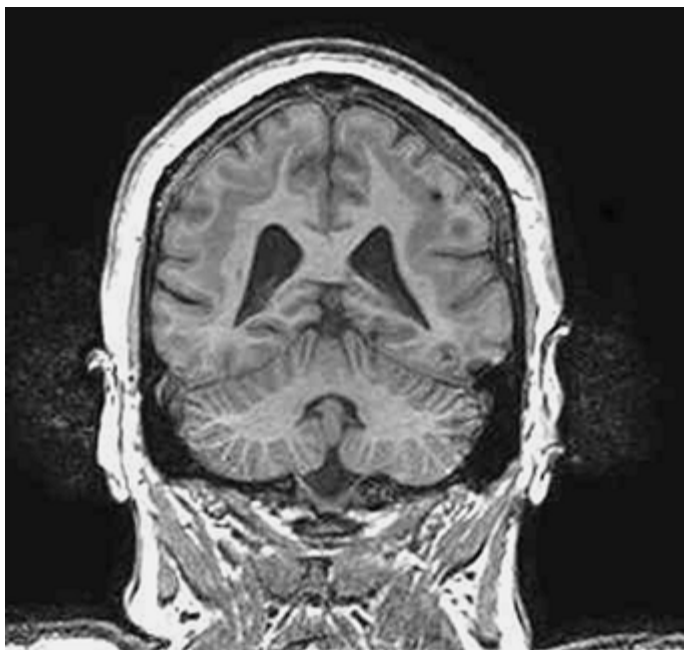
Subcortical band heterotopia (SBH). Coronal T1-weighted image shows typical subcortical band of gray matter with relative normal cortical infolding; *DCX* mutation.
